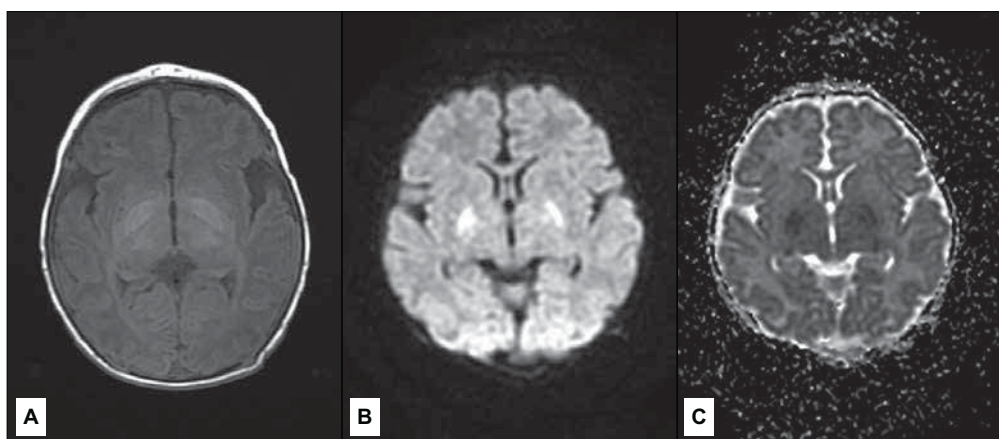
A neonate with acute asphyxia presenting as T1-hyperintensity in the basal ganglia (A) and diffusion restriction (B – DWI sequence, C – ADC map).
